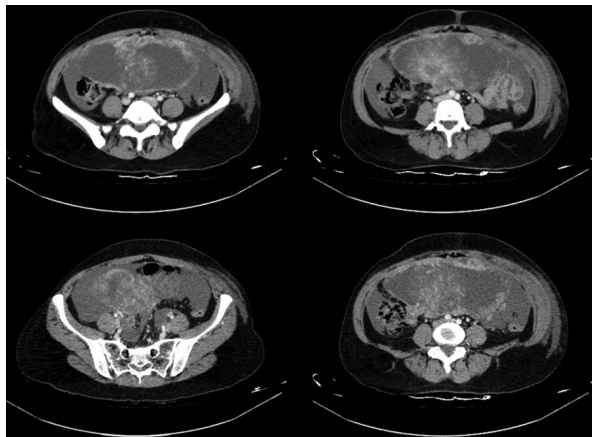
Magnetic resonance image of mesenteric gastrointestinal stromal tumor.
